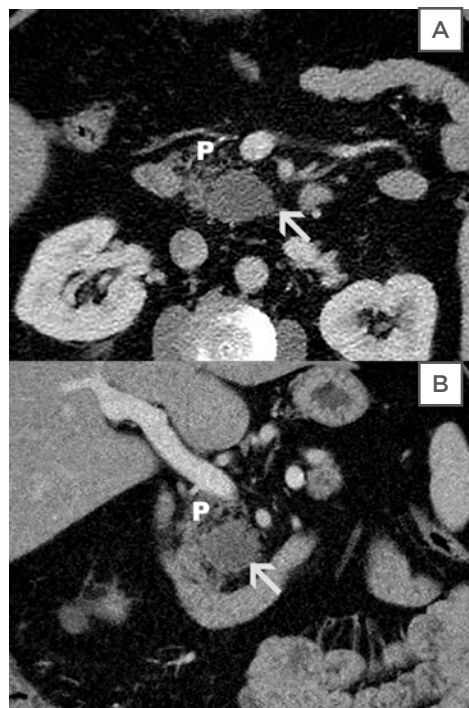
CT images of a lymphoepithelial cyst found in a 65-year-old male.
